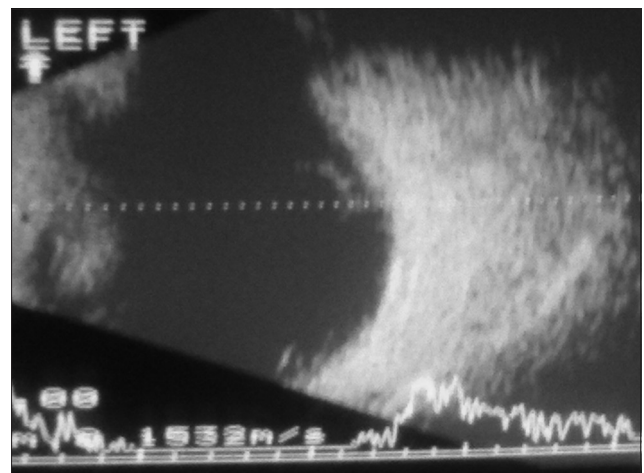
B-scan ultrasonography showing inferior dislocation of intraocular lens with retina attached
